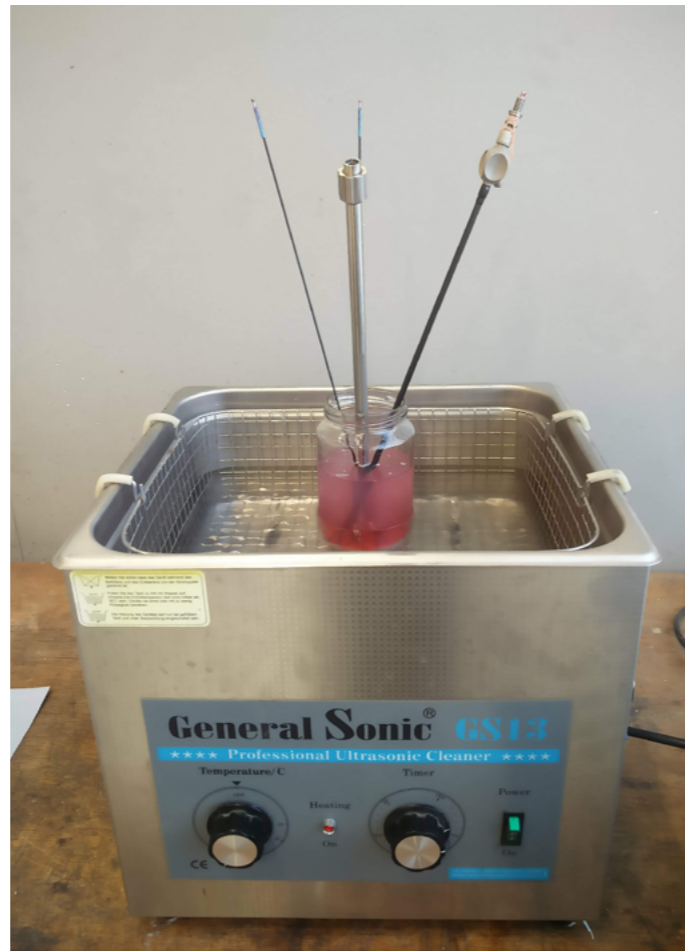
41kHz ultrasonic cleaner.
